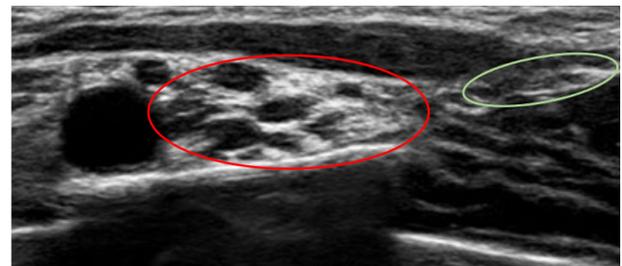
A combination of ultrasound guided and ENS assisted supraclavicular brachial plexus block (red circle) and suprascapular nerve block in anterior approach (green circle). Best combination to get a single entry point for two blocks.
